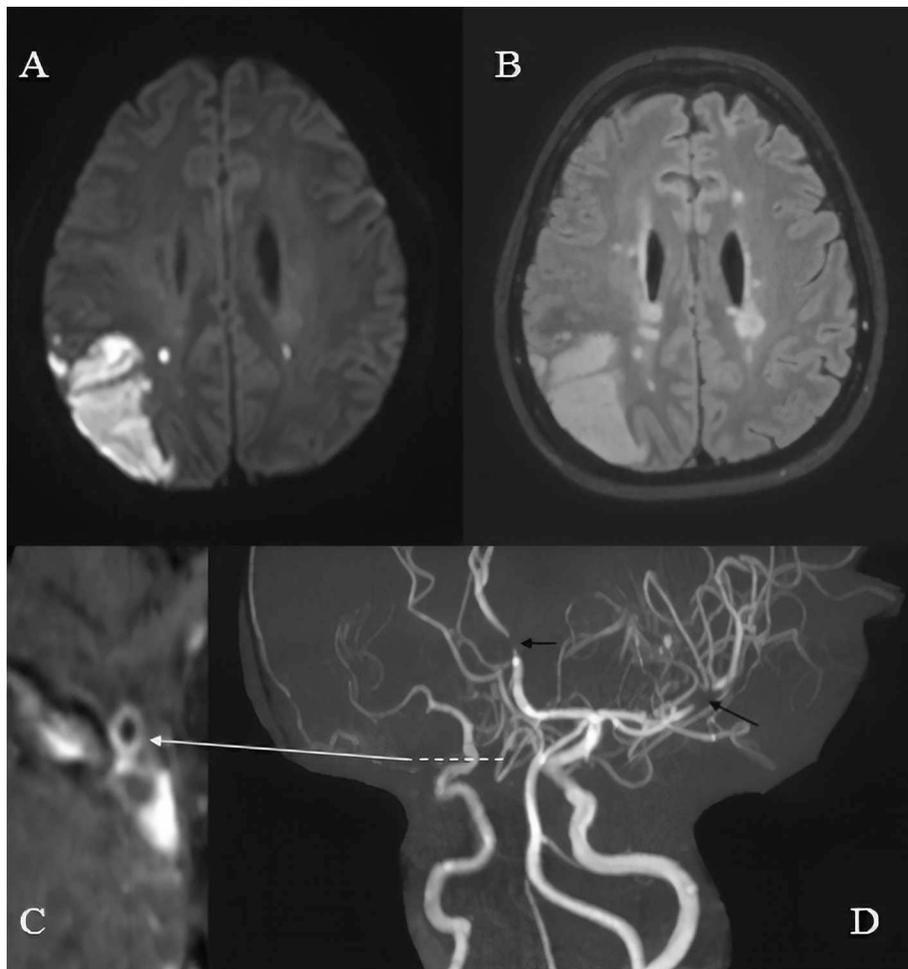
A. MRI diffusion-weighted imaging reveals acute infarction of the right parieto-occipital region. B. MRI FLAIR sequence shows periventricular white matter lesions and infarction of the right parieto-occipital region. C. MRI vessel wall imaging demonstrates concentric enhancement of the right supraclinoid carotid artery (white arrow). D. MRA with gadolinium reveals multifocal intracranial arterial irregularities and stenoses (black arrows).
